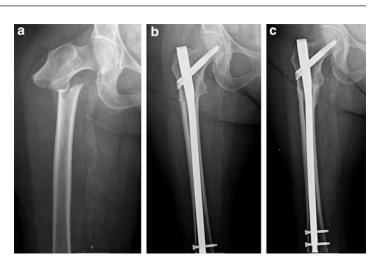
Vignette 3 – atypical hip fracture. (a) Injury radiograph shows a displaced subtrochanteric hip fracture. The fracture line is horizontal in direction. (b) AP radiograph shows the intramedullary hip screw used for fracture fixation. The fracture is well aligned. (c) One-year postfracture radiographs show healing of the fracture with no change in rod position
